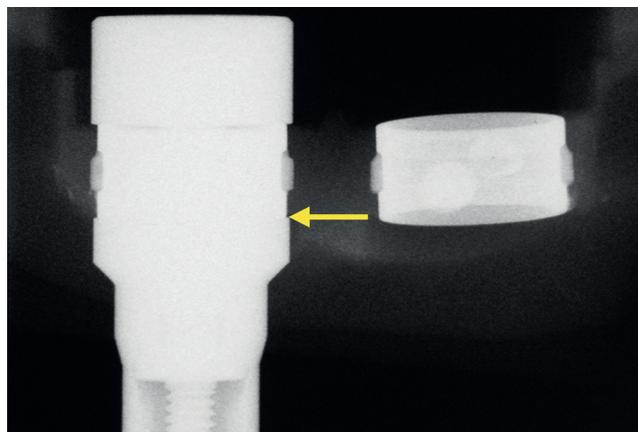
Radiograph confirming complete adaptation.
